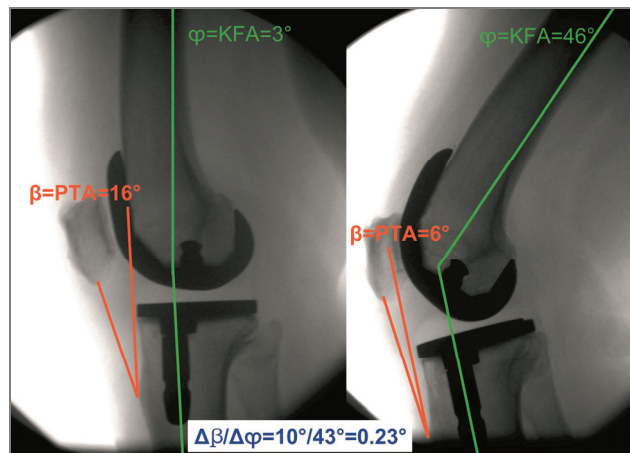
Two X-ray pictures of the same patient with implanted AEQUOS G1. Left – knee nearly in extension: flexion angle  $\varphi = 3^\circ$ . Patellar tendon angle  $\beta = 16^\circ$  (reference: tibia). Right – flexed knee,  $\varphi = 46^\circ$ . The patellar tendon pivoted backwards by  $10^\circ$  around its insertion at the tibial tuberosity:  $\beta = 6^\circ$
